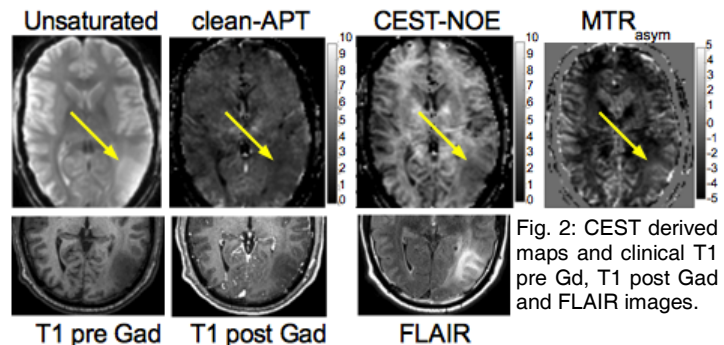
CEST derived maps and clinical T1 pre Gad, T1 post Gad and FLAIR images.
